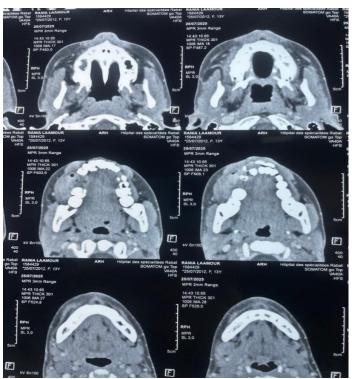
Contrast-enhanced CT of the upper right gingival mass demonstrating a well-circumscribed lesion with heterogeneous enhancement and areas of vascular flow voids
